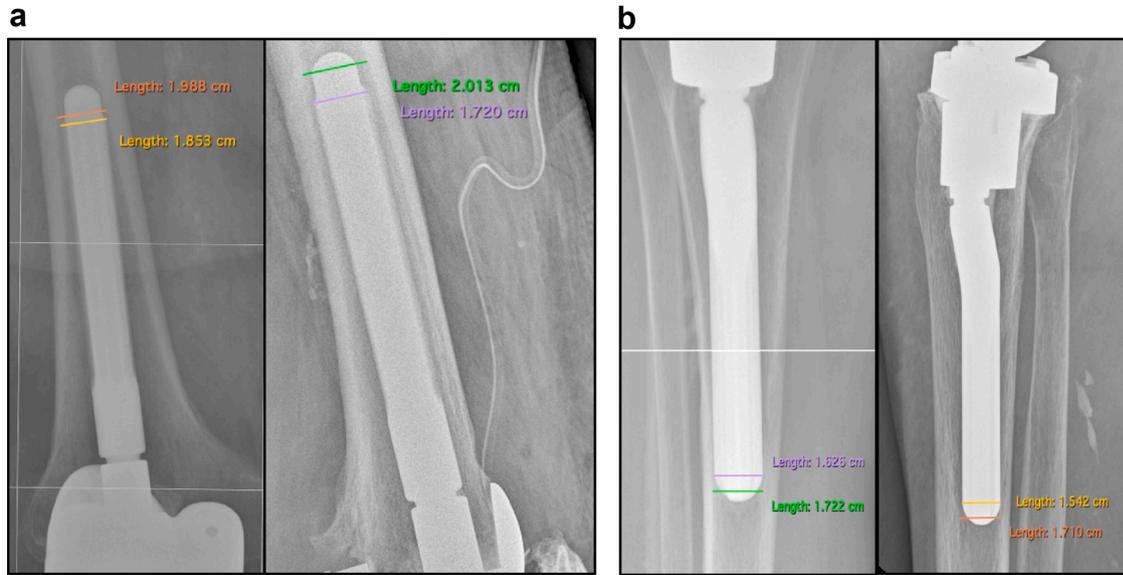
Radiographic assessment of postoperative measurements of the canal fill ratio, (a) Femoral stem AP and lateral views; (b) Tibial stem anteroposterior and lateral views.
